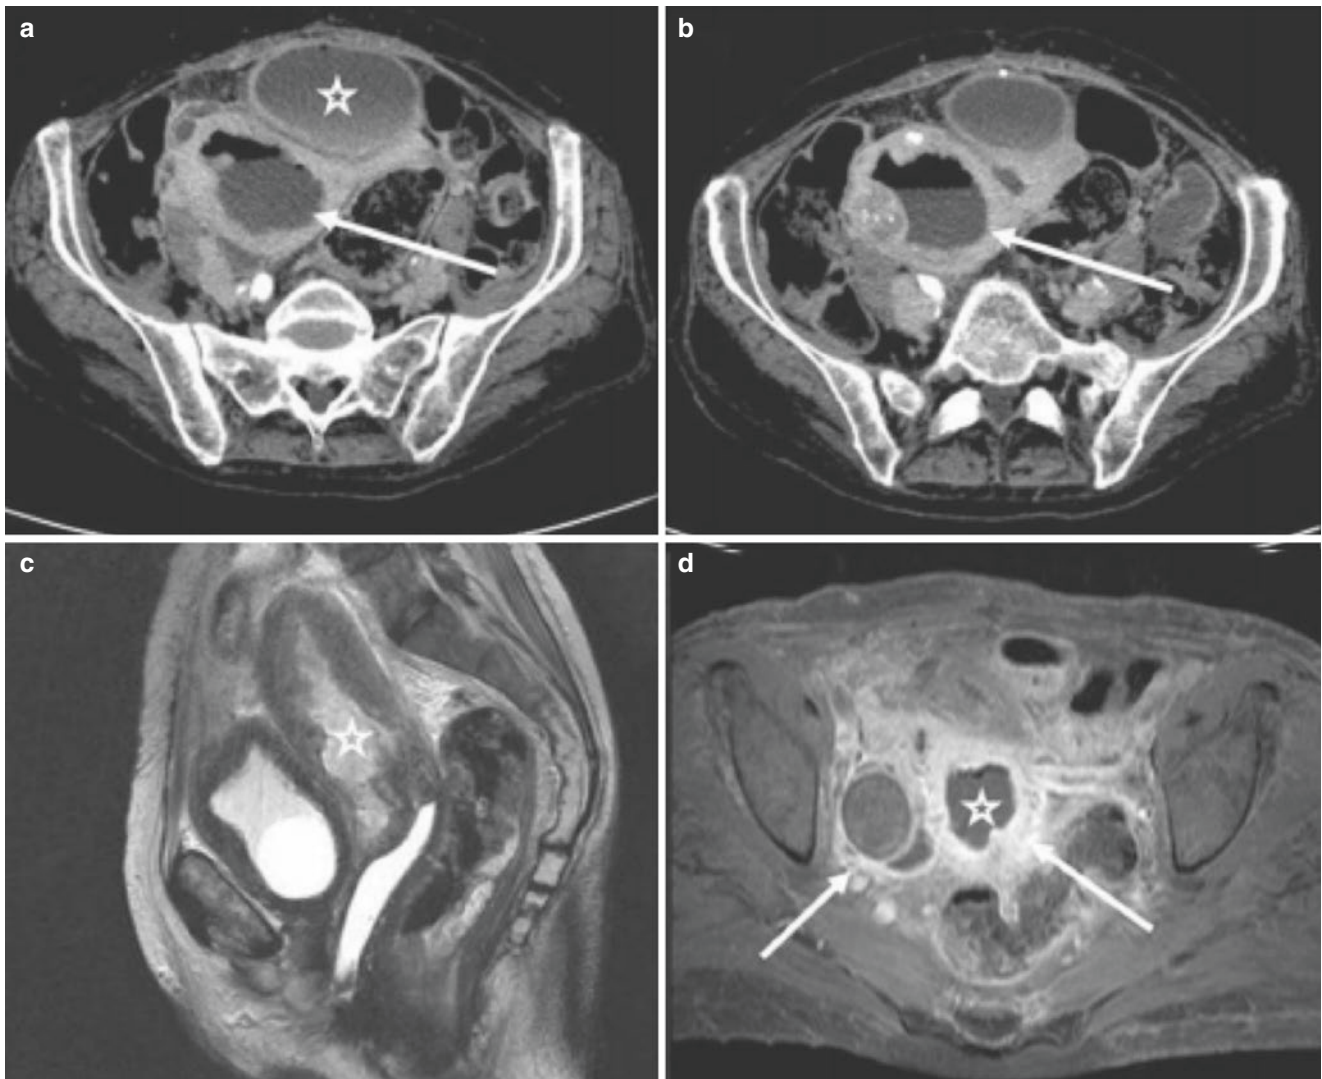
Severe PID shown by CT (a, b) and MR (c, d). Extensive and diffuse thickening of the endometrium can be noted, with air-fluid level in the uterine cavity (*arrows a, b*). Also heterogeneous collection in front of the uterus, with thick walls, and exhibiting moderate enhancement by contrast is associated (*star a*). The MRI shows thick material in the uterine cavity (*stars c, d*) as well as enhancement of adnexal structures (*arrows d*). (a, b): axial sections obtained in the portal phase;
